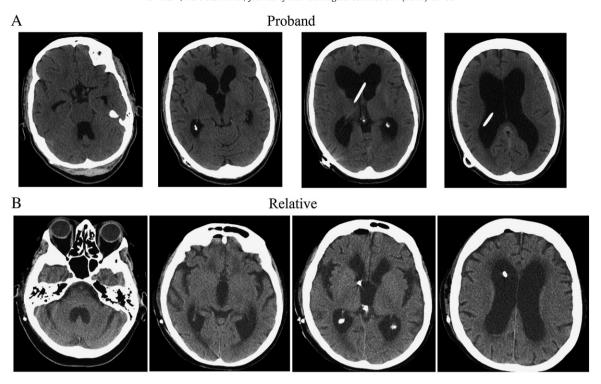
Case report post-operative imaging. A) Proband post-operative CT imaging 36 months post- CSF diversion surgery demonstrating stable ventriculomegaly. B) Relative post-operative CT imaging one week post-surgery demonstrating stable ventriculomegaly and the interval placement of the shunt.
